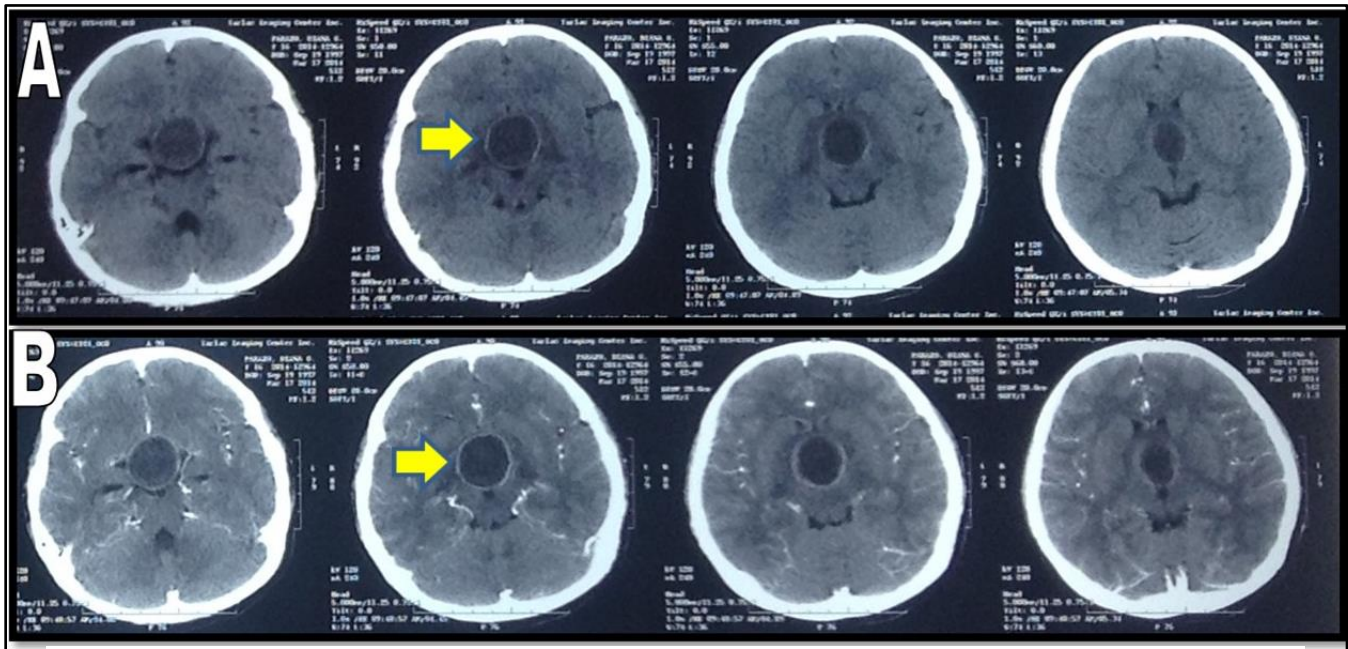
A) Plain cranial CT scan showing hypodense lesion (yellow arrow) measuring 3x3cm at the sellar-suprasellar area. B) Contrast study showing marginal enhancement of the lesion.
